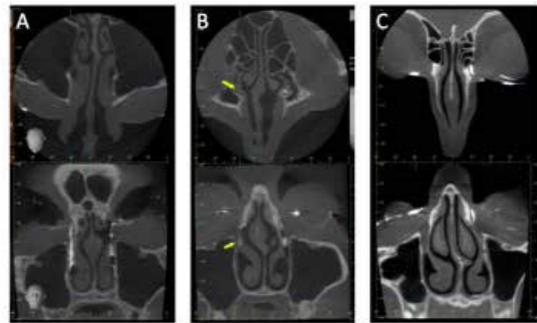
Representative images from CBCT DCG. Each panel demonstrates axial (above) and coronal (below) slices. A. patent right lacrimal excretory system. Left side with patent drainage of contrast material with evidence of previous dacryocystorhinostomy. B. Total nasolacrimal duct obstruction on the right, yellow arrows denote position of nasolacrimal duct. C. Right canalicular obstruction.
